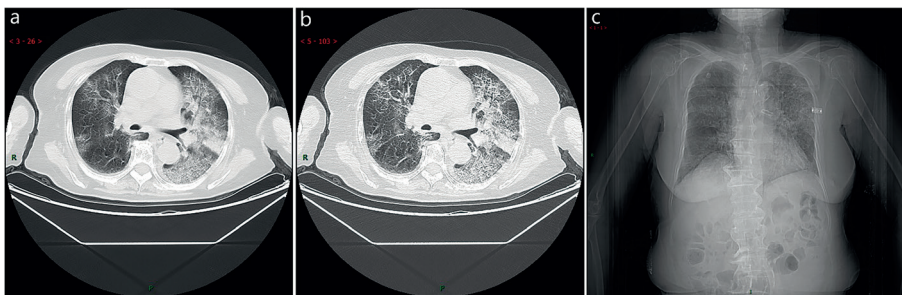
Atypical CT / X-ray imaging manifestation (case 1). An 83 years old female with fever for 4 days (maximum temperature of 38.8 °C), cough, chills, sore throat, dry cough for 1 week, chest tightness and shortness of breath aggravating for 1 week. Laboratory test: normal white blood cells ($4.6 \times 10^9/L$), normal neutrophil percentage (65.8%), decreased lymphocytes percentage (19.9%). Imaging examination: a and b showed diffuse interlobular septum thickening in both lungs to form a grid opacity, thickening of bronchial wall, and consolidation in the left sublobar lung. c showed diffused grid-like opacities in both lungs, especially in the left lung
